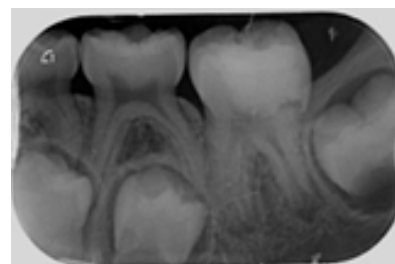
Initial periapical radiograph of 3.6*
